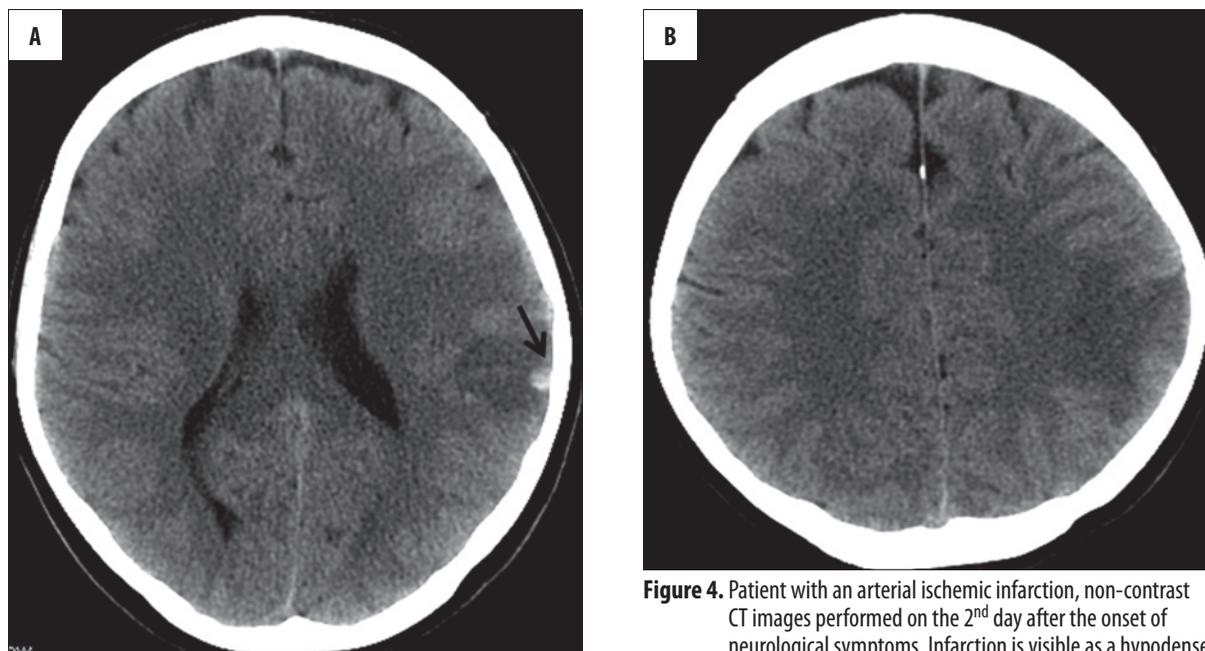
Patient with an arterial ischemic infarction, non-contrast CT images performed on the 2nd day after the onset of neurological symptoms. Infarction is visible as a hypodense lesion within cortex of the left temporo-parietal area (A, B). Small peripheral hyperdense dot (arrow) represents an area of hemorrhage not a thrombosed cortical vein (A).
